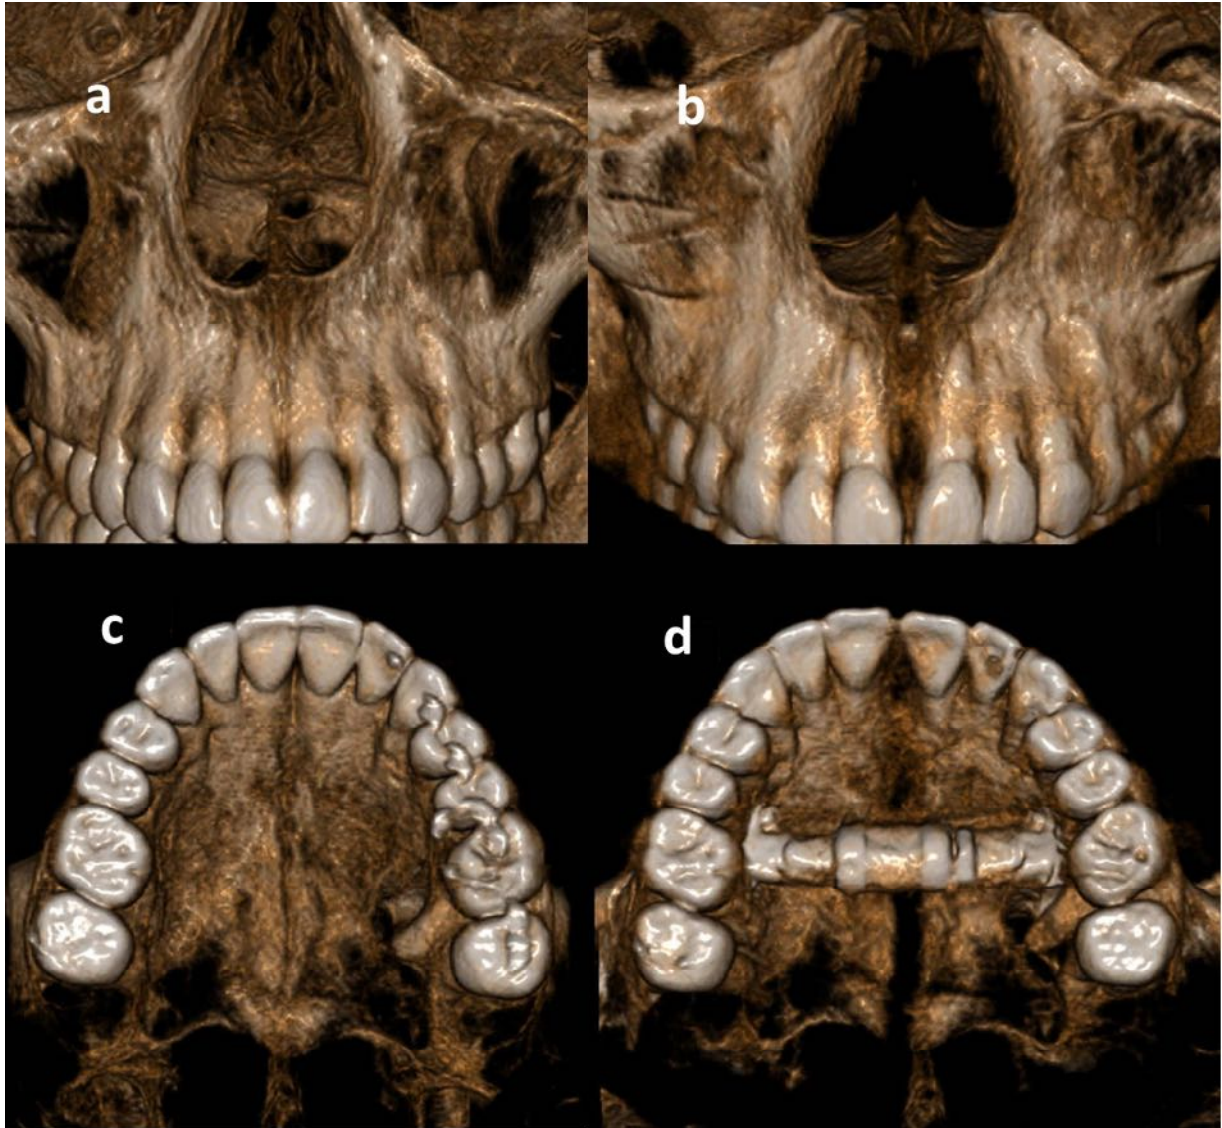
CBCT of the patient in Figure 2. (a) Preoperative frontal view. (b) Postoperative frontal view at the completion of expansion showing a 5 mm opening at the ANS. (c) Preoperative palatal view. (d) Postoperative palatal view at the completion of expansion showing a 5 mm opening at the PNS. Note the small dental diastema.
